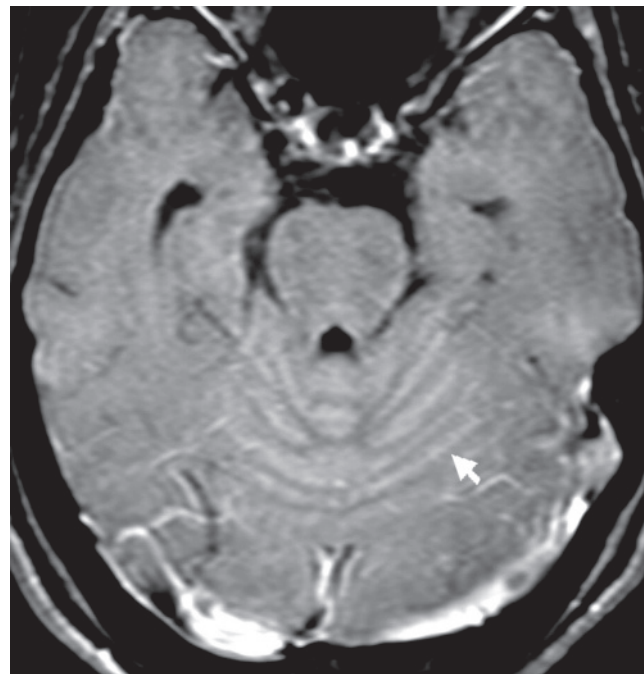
Post contrast T1W axial sequence of MRI of brain of a 45 years old lady with cytology positive neoplastic meningitis secondary to unknown primary shows leptomenigeal enhancement in the region of cerebellar folia.
